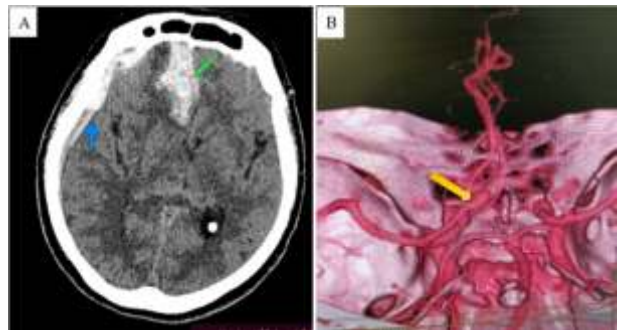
A) Initial CT showing an aSDH (blue arrow) and the typical frontal lobe hematoma (green arrow). B) CT angiography shows an anterior communicating artery (AcomA) aneurysm.
